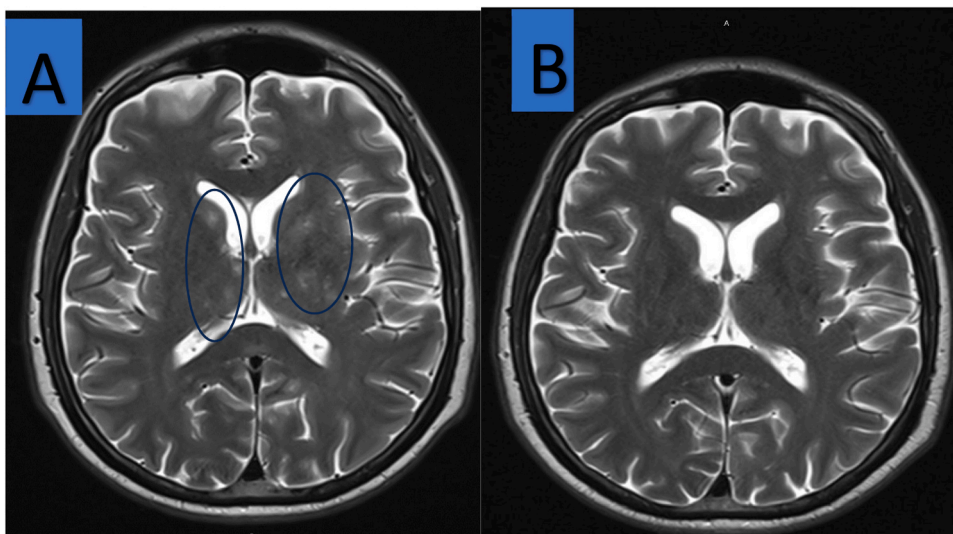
MRI brain with intravenous gadolinium showing asymmetrical multifocal T2 hyperintense foci. Some are showing ring enhancement (A). Repeat MRI brain with IV gadolinium on day 24 showing resolution of microabscesses(B).
